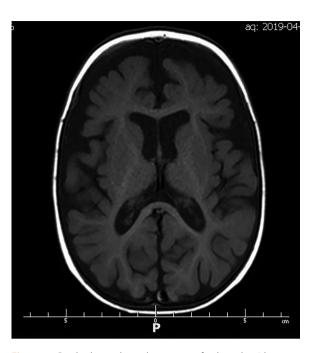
Cerebral atrophy, enlargement of subarachnoid spaces, delayed myelination (magnetic resonance imaging of the central nervous system in axial T1-weighted SE image)
